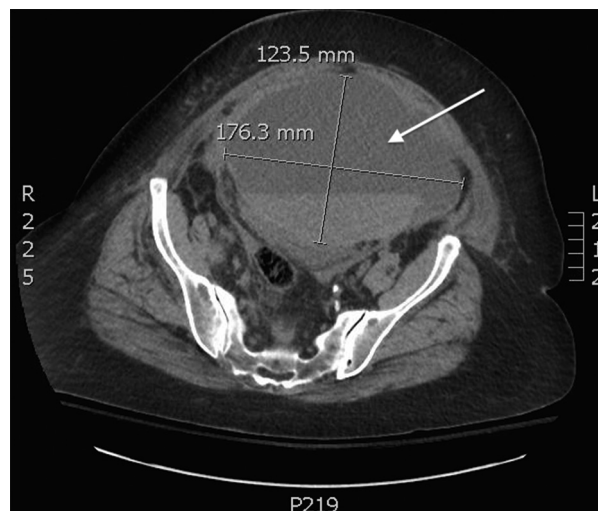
Arrow pointing to pelvic hematoma seen on axial slice from a computed tomography scan of abdomen and pelvis with intravenous contrast.
